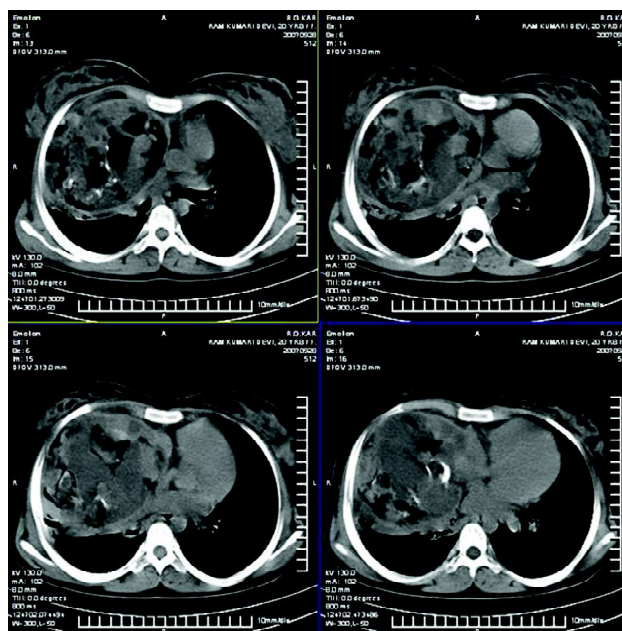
Heterogeneity of the mass (teratoma) in CT of thorax.
